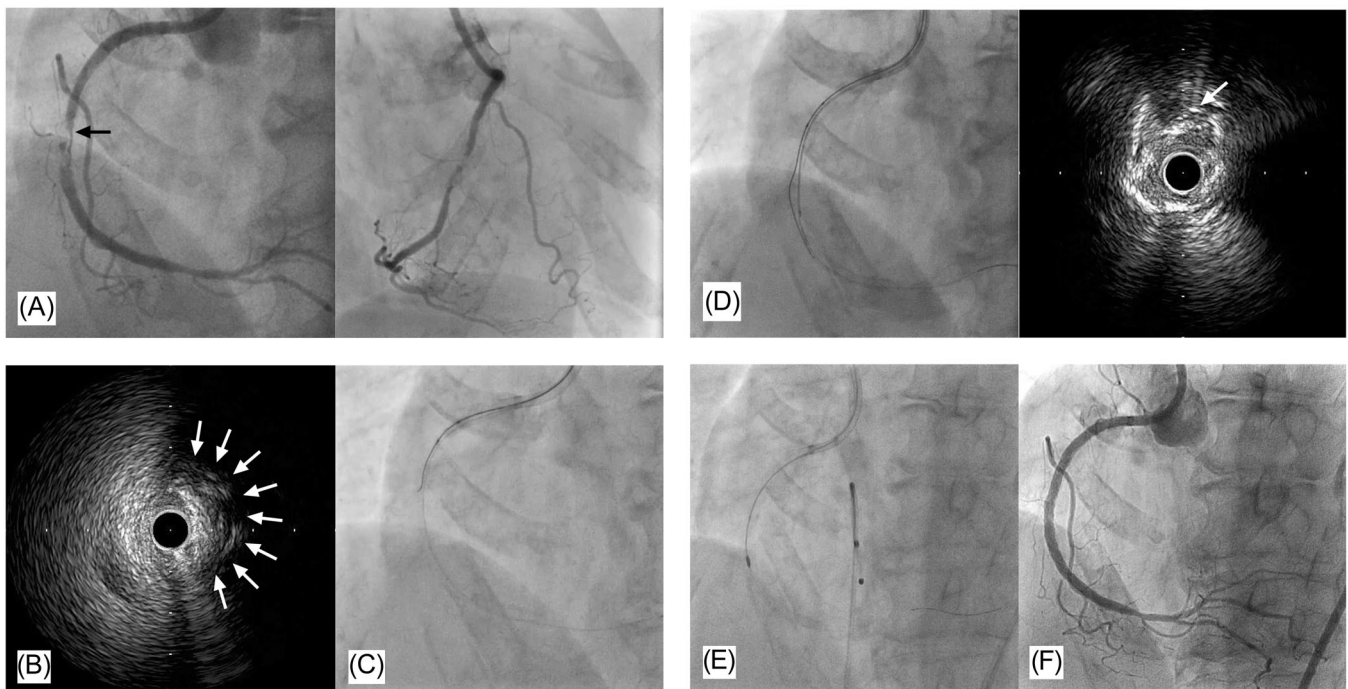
Case 2. (A) Initial CAG LAO view and RAO view before PCI. (B) IVUS image from sub-lumen; arrows indicate true-lumen calcified nodule. (C) Angiography-based 3D wiring with the CP12ST. (D) The CP12ST into true-lumen is confirmed by IVUS. (E) Rotational atherectomy under temporary pacing. (F) Final CAG LAO view. CAG, coronary angiography; CP12ST, Conquest Pro 12 Sharpened Tip; IVUS, intravascular ultrasound; LAO, left anterior oblique; RAO, right anterior oblique; PCI, percutaneous coronary intervention.
